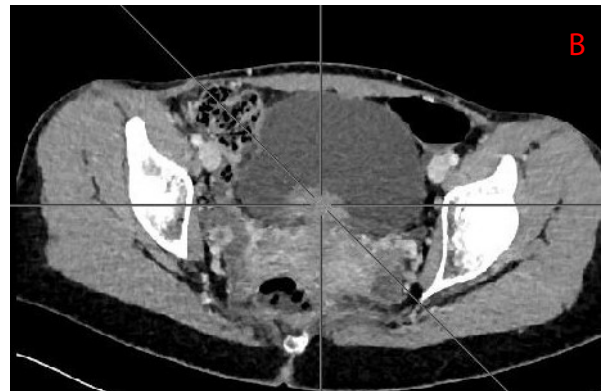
Abdominopelvic CT scan
